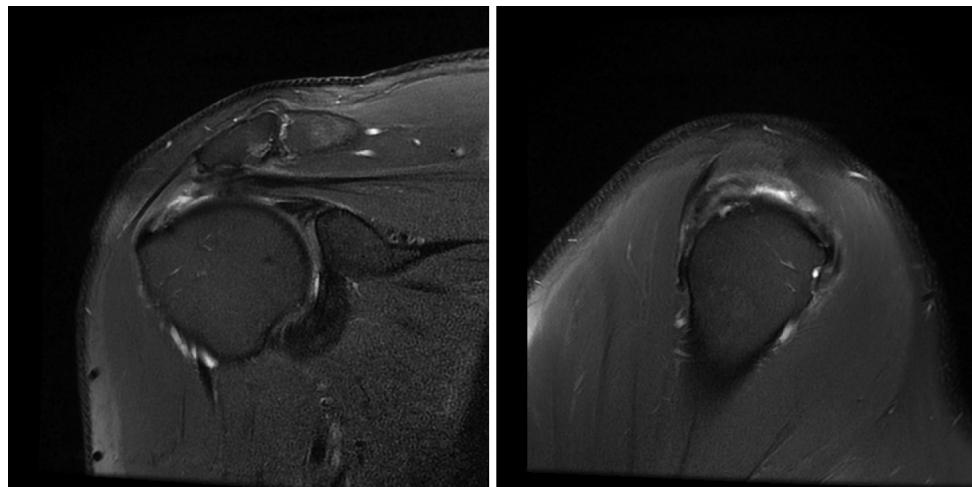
Preoperative MRI images confirming a full-thickness supraspinatus tear. *MRI*, magnetic resonance imaging.
